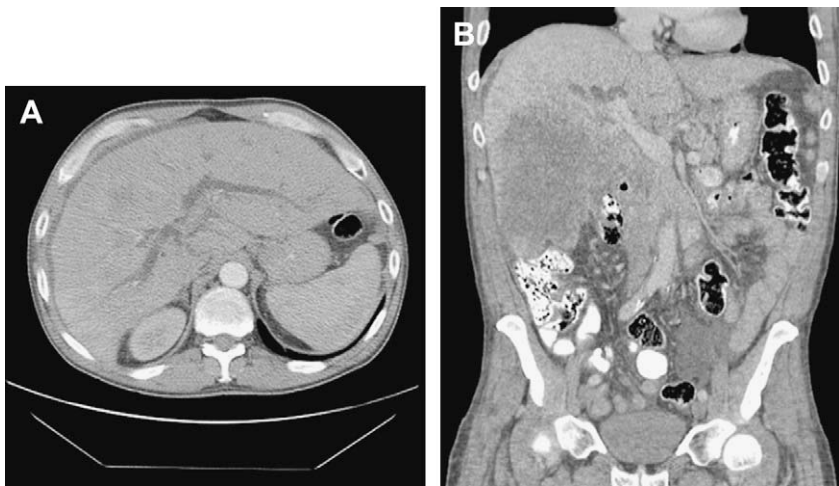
A 54-year-old man who had unresectable cholangiocarcinoma and biliary obstruction. (A) Axial and (B) coronal CT images showing biliary ductal dilatation with extensive right lobe and porta hepatis involvement, leading to left-sided approach to drainage.
